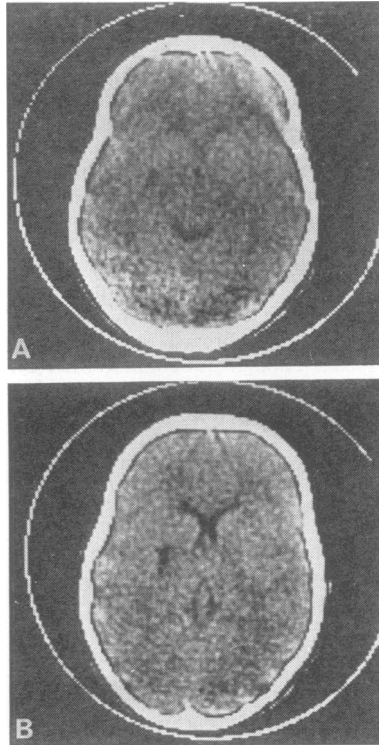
Figure CT scan shows a narrow band of low attenuation extending laterally into the left putamen from the posterior limb of the internal capsule (A: cut 4A; B: cut 4B; 1 cm above A).
